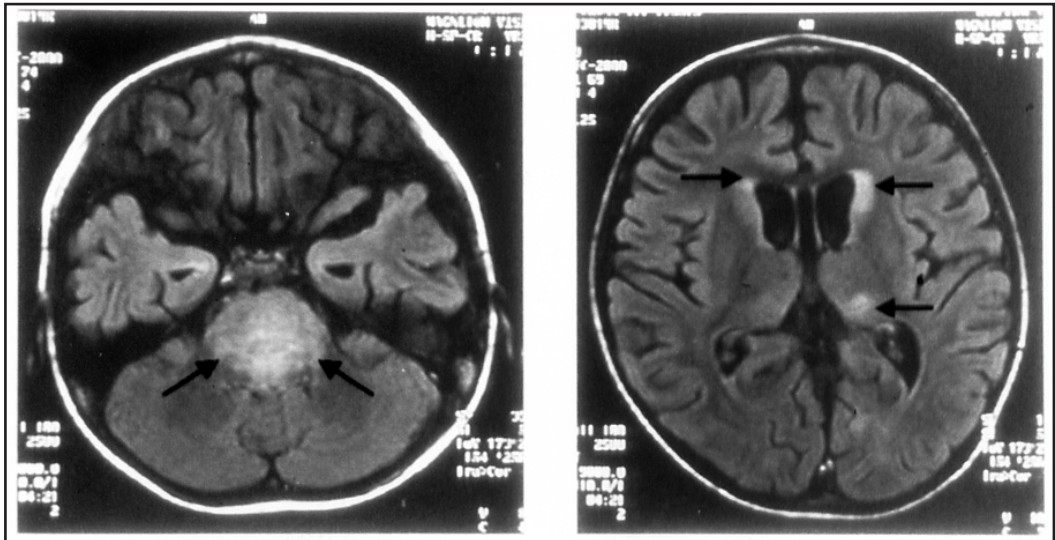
MRI images of the brain at diagnosis. (A) T2-FLAIR image shows a hyperintense pons (arrows). (B) A higher slice shows hyperintense areas in the caudate nuclei and left thalamus (arrows)
